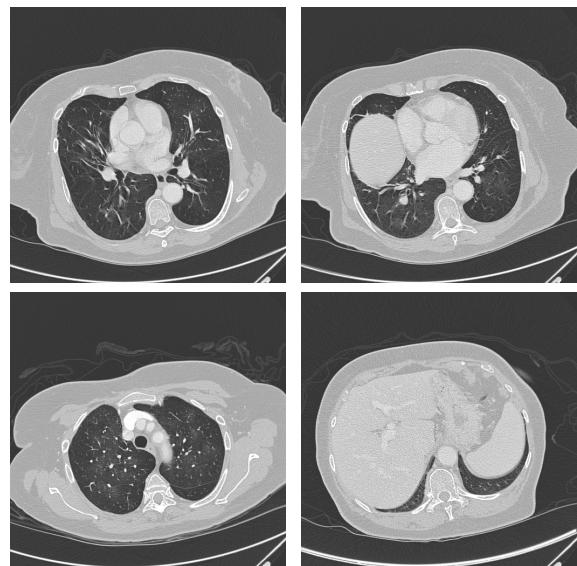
Example CT images containing lungs of various shapes and characteristics.
